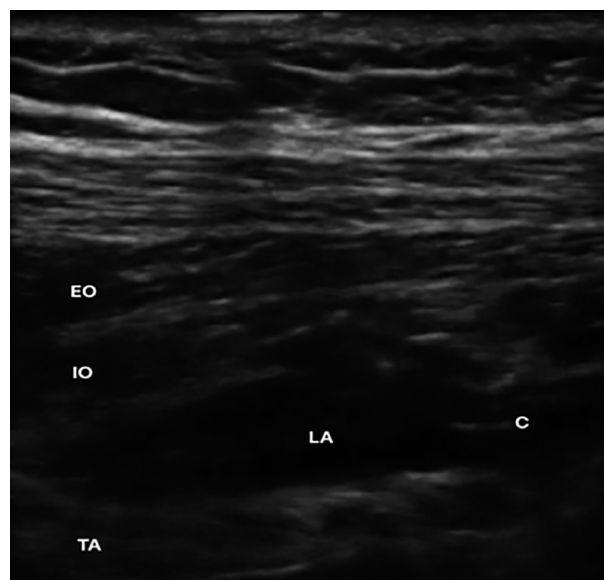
Ultrasound image of the postero-lateral area of the abdominal wall after insertion of the catheter (C) in the posterior transversus abdominis plane. EO = external oblique muscle, IO = internal oblique muscle, TA = transversus abdominis muscle, LA = local anesthetic. Front is left and back is right.
